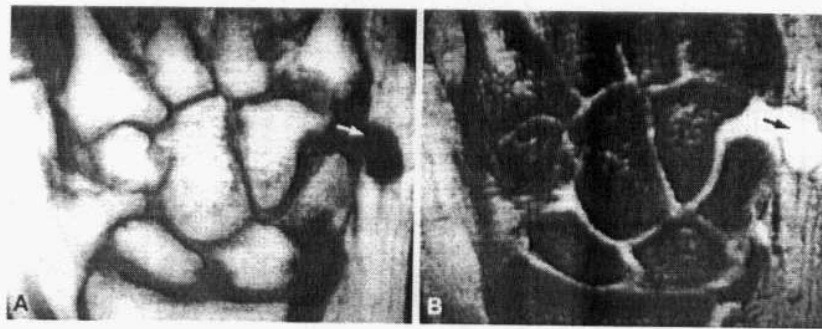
Synovial cyst (arrows) communicates with the hamate triquetral joint. The lesion demonstrates (A) low signal intensity on a T1-weighted coronal image and (B) hyperintensity on a T2*-weighted coronal image (Quoted from Stoller and Brody, 1997).
